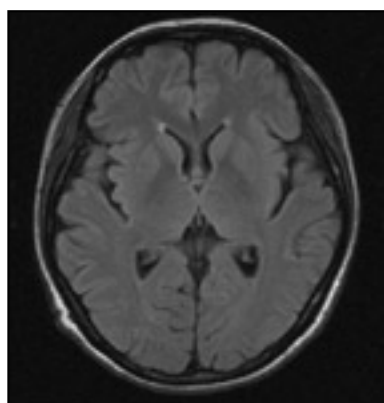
Axial FLAIR (fluid attenuated inversion recovery) image on follow-up magnetic resonance imaging 4 months later demonstrating complete resolution of the T2 hyperintense lesions on both sides of the parieto-occipital region of the brain
